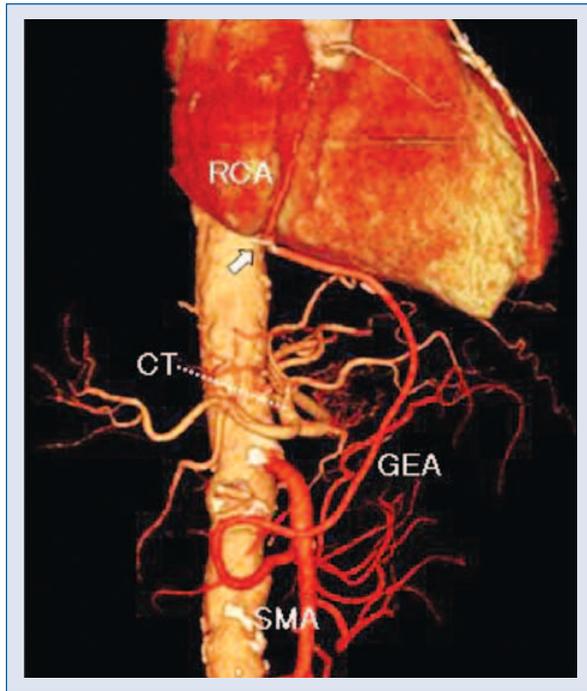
Volume-rendered image highlighting the anomalous right gastroepiploic artery (GEA) graft arising from the superior mesenteric artery (SMA). Arrow indicates the point of GEA anastomosis; CT — celiac trunk; RCA — right coronary artery.
